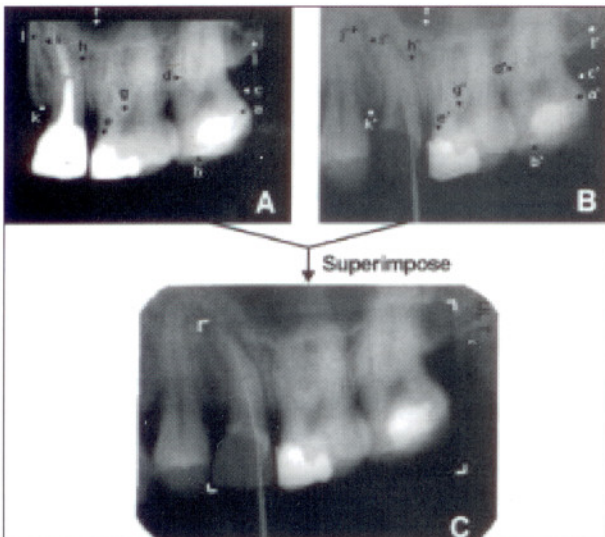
Comparison of X-ray images. A: post-mortem digital X-ray image. B: ante-mortem X-ray photograph. Many identical points (a:a' - k:k') were found. C: superimposition of images A and B.
